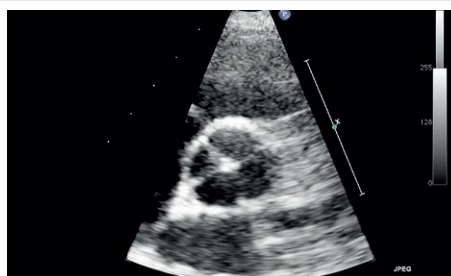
Echocardiographic study showing the QAV of case 1.
